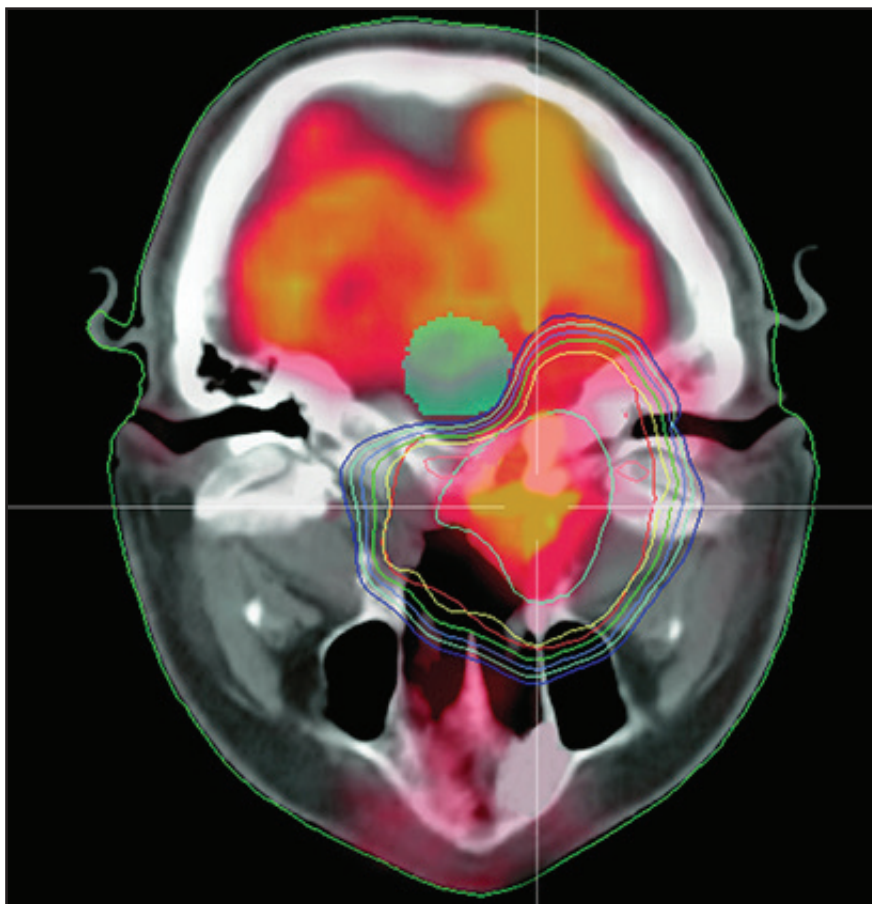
A blended CT and PET image, showing a cross section of the head in the nasal cavity area. This image was co-registered using Eclipse™ treatment planning software. The white cross hairs come together at the tumor site. The lines around the tumor are part of an IMRT treatment plan, and show that the highest radiation dose is being in concentrated right in the tumor, with the dose falling off rapidly as you move away from the tumor. This plan was designed for maximum preservation of the brain stem, which in this case is avoided altogether.
